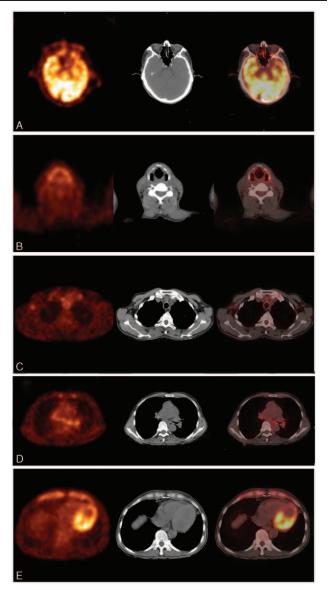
PET images (left), unenhanced CT images (middle), and the PET/CT fusion imagings (right) of auricle, larynx, trachea, and all costal cartilages and the axillary, hilum, and mediastinal lymph nodes, respectively. CT = computed tomography, PET = positron emission tomography.
